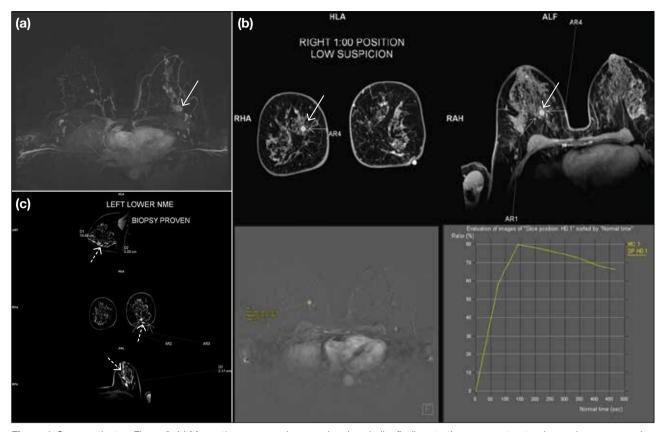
Same patient as Figure 3. (a) Magnetic resonance images showing similar findings to those on contrast-enhanced mammography. (b) Enhancing lesion in the upper inner quadrant of the right breast (arrows) with restricted diffusion and a type III curve, suspicious for malignancy. (c) Lower central enhancing lesion in the left breast corresponding to the biopsy-proven malignancy (not shown in [c], arrow in [a]), associated with segmental clumped non-mass enhancement (dashed arrows).
